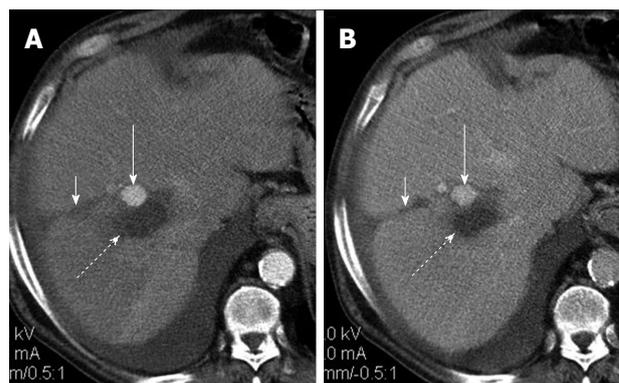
Arterial pseudoaneurysm after radiofrequency ablation for hepatocellular carcinoma. Post-treatment arterial phase (A) computed tomography (CT) shows a round enhancing area (long arrow) anterior to ablated zone (dotted arrow) with persistent enhancement on portal venous phase (B) CT. Round shape, isoattenuation to aorta and absence of wash-out suggest diagnosis of iatrogenic pseudoaneurysm. Note probe track (short arrow on A and B).
